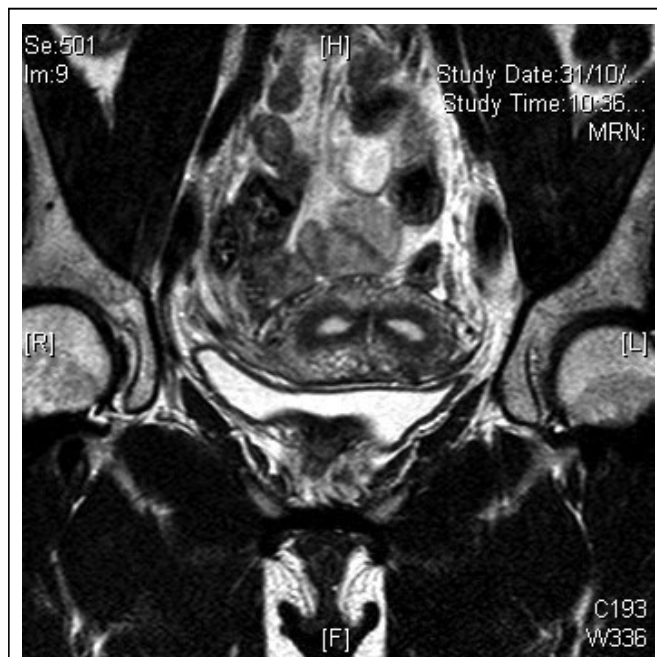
MRI scan identifying separate uterine cavities
